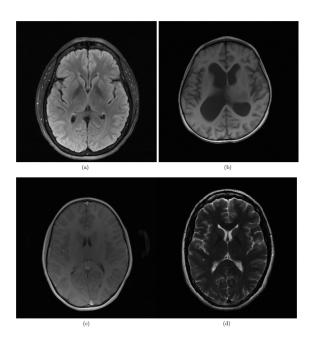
Axial brain slices with FLAIR (a), T1 weighted (b), T1 POST (c) and T2 weighted (d). Each protocol allows to highlight different structures. [8]
